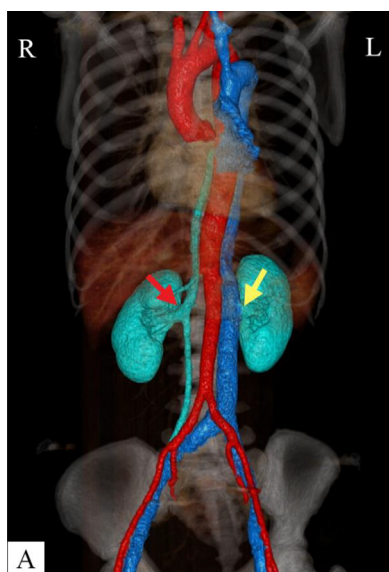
The patient’s CT VR images. (A) The right renal vein (red arrowhead) flows back into the azygos vein, and the left renal vein (yellow arrowhead) drains directly into the left inferior vena cava. The left inferior vena cava runs behind the left side of the descending aorta.
